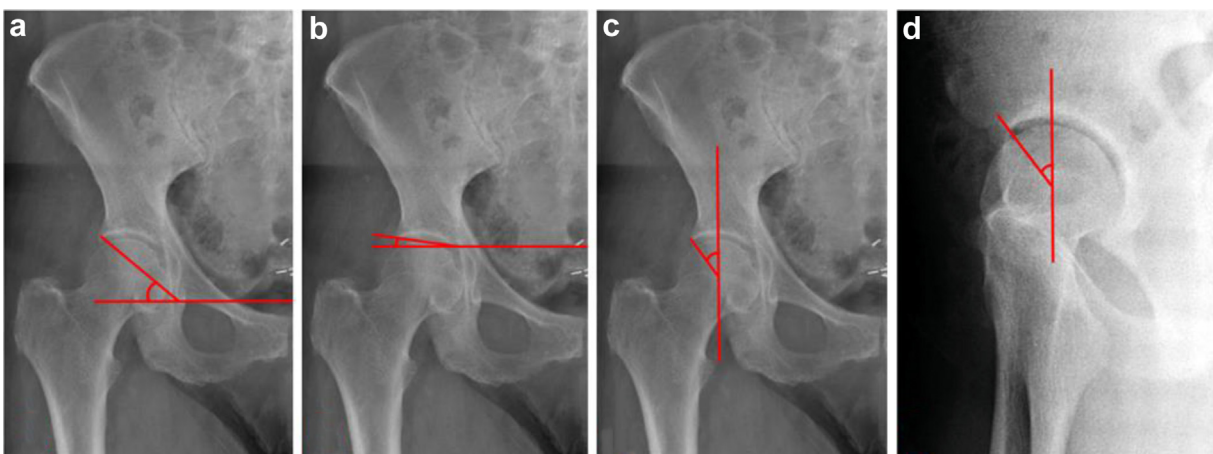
Selection of previously validated plain radiographic measures. (a) Acetabular Index of Sharp (SA); (b) Sourcil angle of Tönnis; (c) lateral center edge angle of Wiberg (LCEA); (d) anterior center edge angle of Lequesne and de Seze (ACEA).
